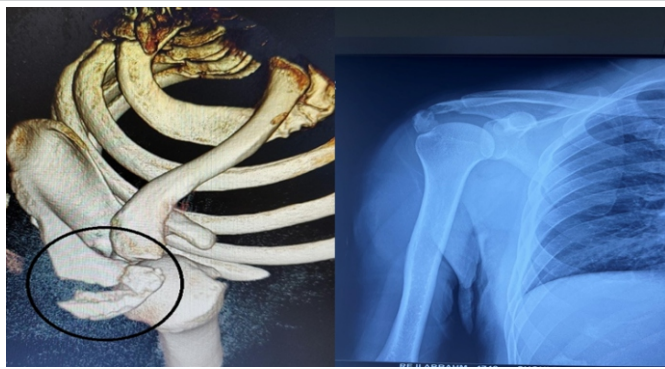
Pre-operative X-ray and 3D CT images
